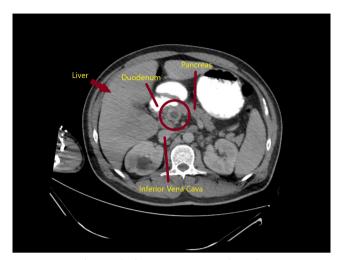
In the axial plane CT image with oral-IV contrast, a central luminally located, hypoattenuating thrombus causing a filling defect in the portal vein is observed (red circle) *CT: Computed tomography*
